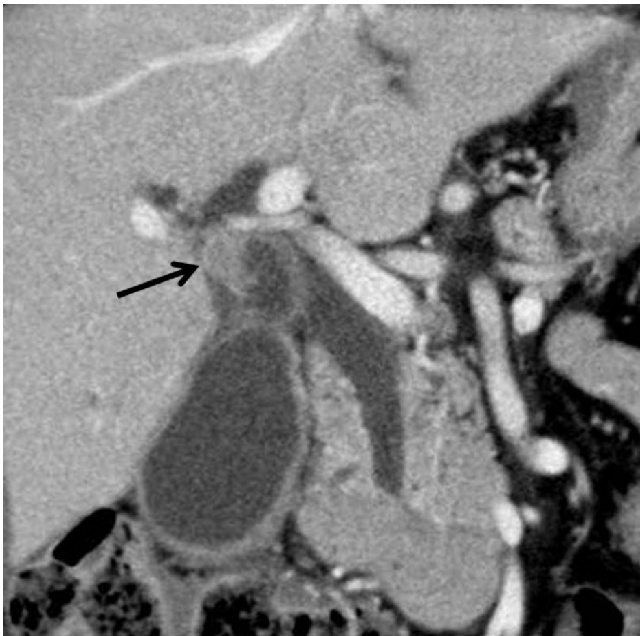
Enhanced computed tomography showed a hypervascular tumor, 10 mm in diameter, in the cystic duct.
